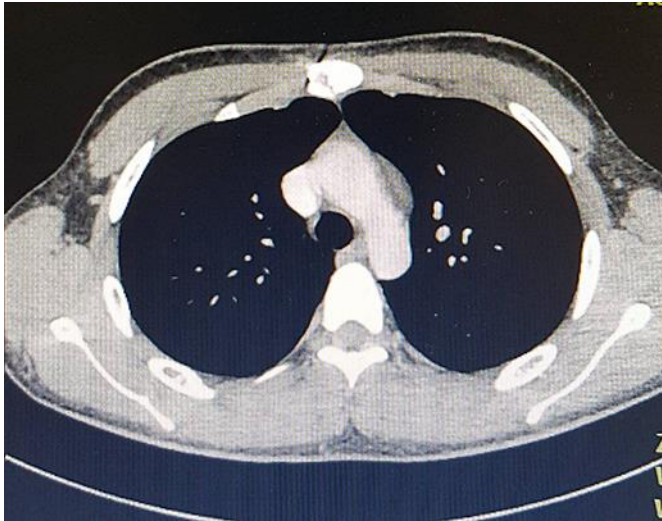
The results of a chest CT scan in case I showed normal thymic morphology.
